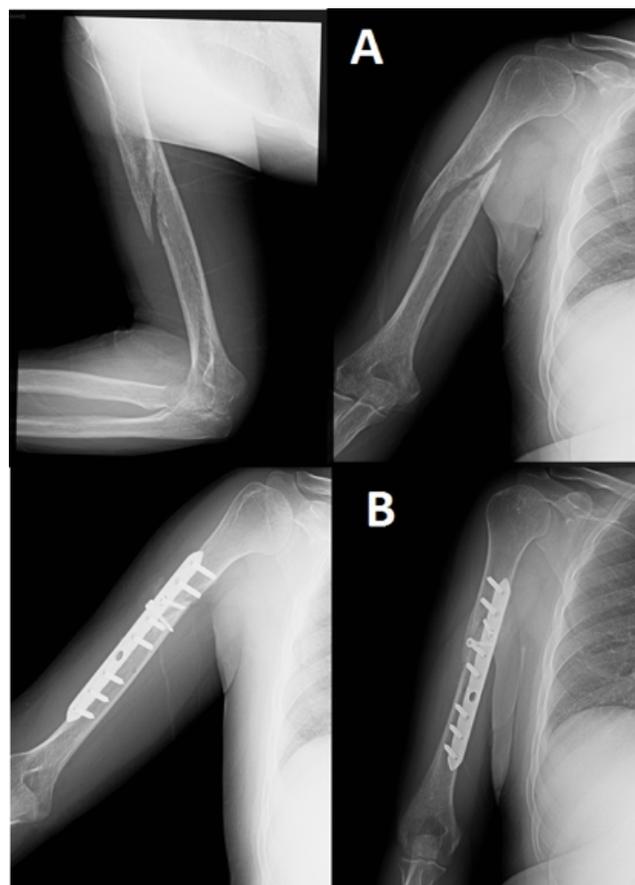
Images of a 48-year-old male patient whose closed fracture of the humerus had been treated conservatively. (A) Anteroposterior and lateral radiographs taken seven months after the primary intervention showing the nonunion. (B) Radiological union was achieved 15 weeks after our surgical intervention with LCP fixation and autografting.
